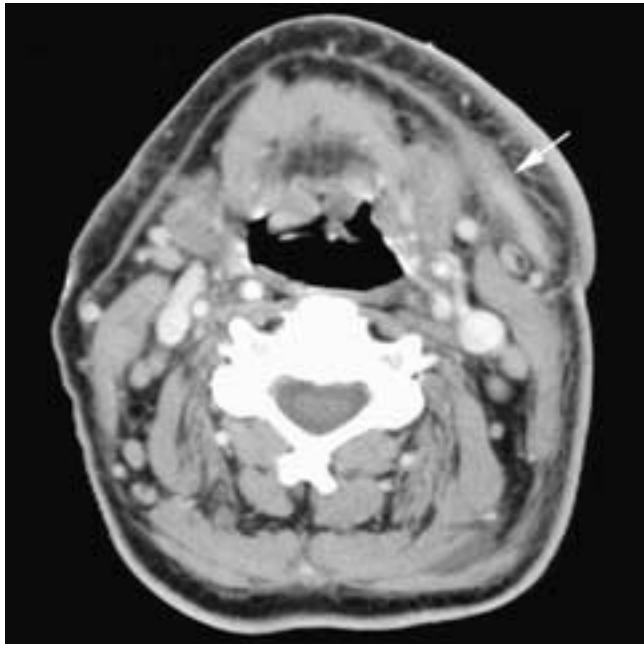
Axial contrast-enhanced CT scan shows cellulitis in the left neck. There is thickening of the skin, widening of the subcutaneous fat with increased attenuation, and thickening of the platysma (arrow) as a result of an inflammatory myositis.
